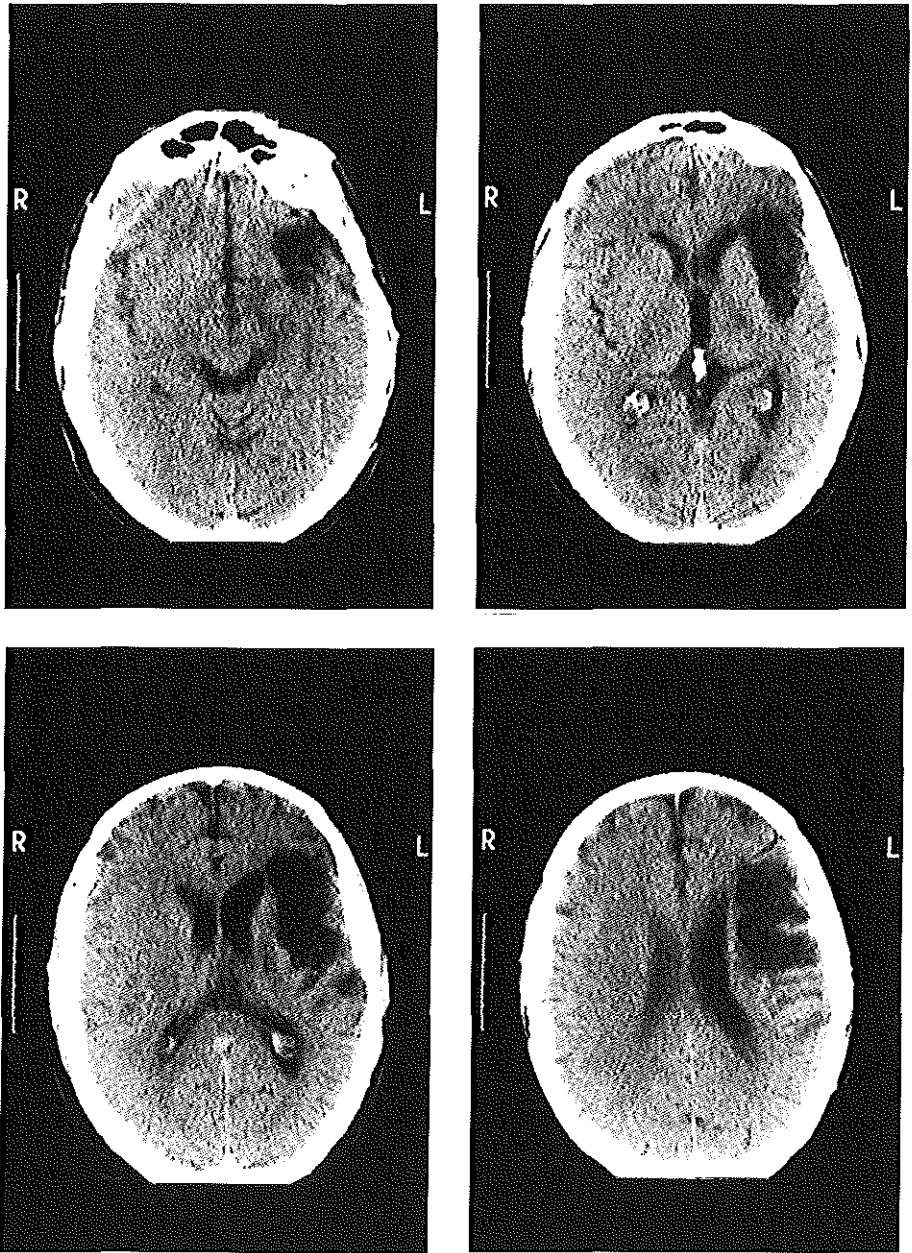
CT scan data AL, one year post onset
